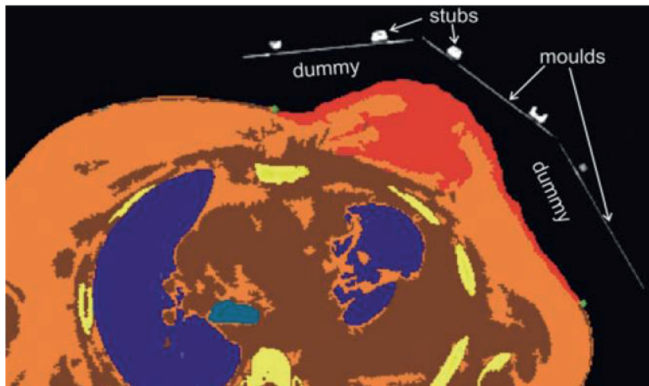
Moulds representing LCA footprints (not segmented) with stubs turned up-side down on top of a dummy water bolus (not visible on CT scan).
